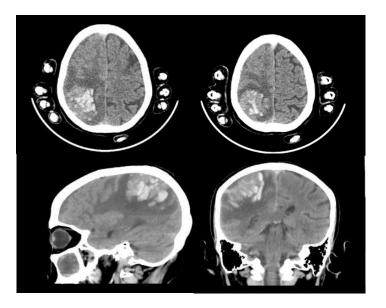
CT-scan image of the head without contrast
